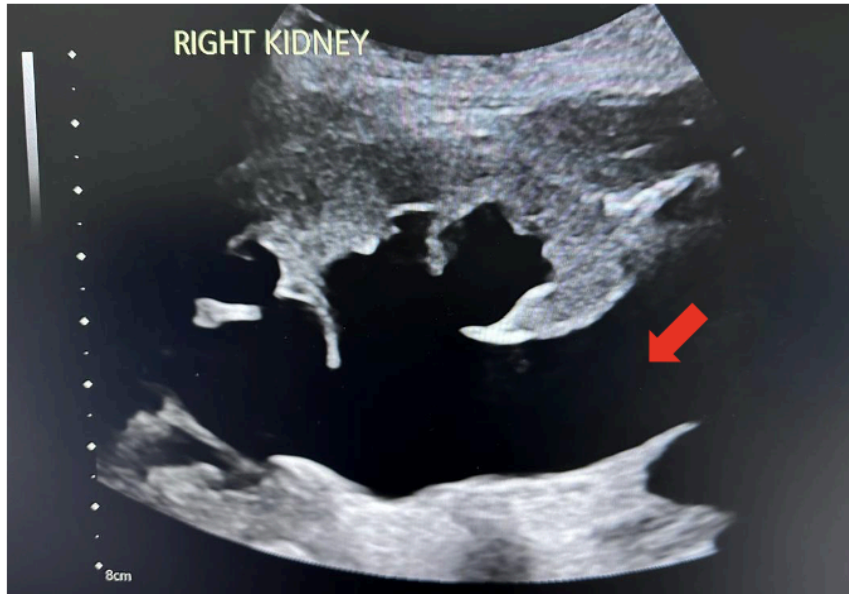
Renal ultrasound demonstrating grade IV hydronephrosis affecting the right renal pelvis and calyces, with significant dilatation of the proximal ureter (red arrow).
